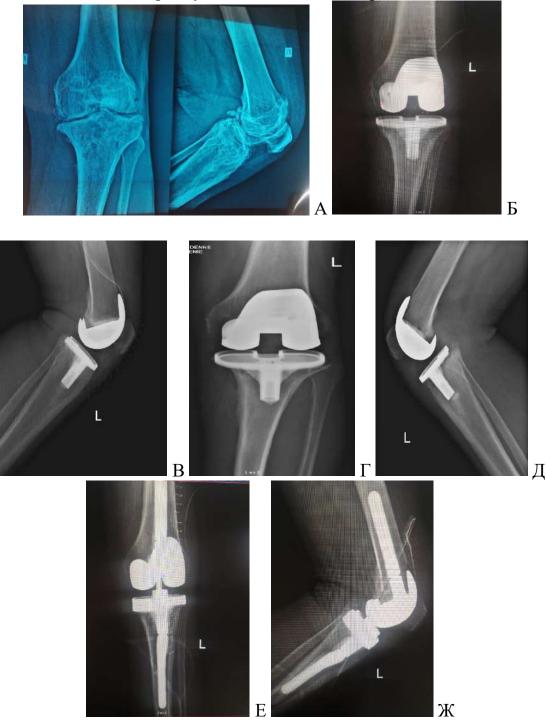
X-rays of patient B., 56 years old. A — osteoarthritis of the left knee joint of the III st. B, C — X-rays after knee replacement. D, D — X-rays after 6 months - aseptic instability of the arthroplasty. F, F — removal of implant components, installation of a revision arthroplasty LSSC
